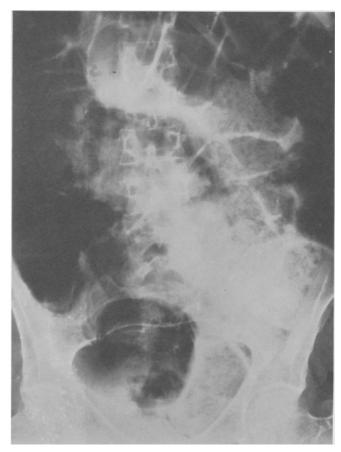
X-ray of the abdomen showing colon dilatation ten years after sigmoid colectomy for volvulus (Case 31).
